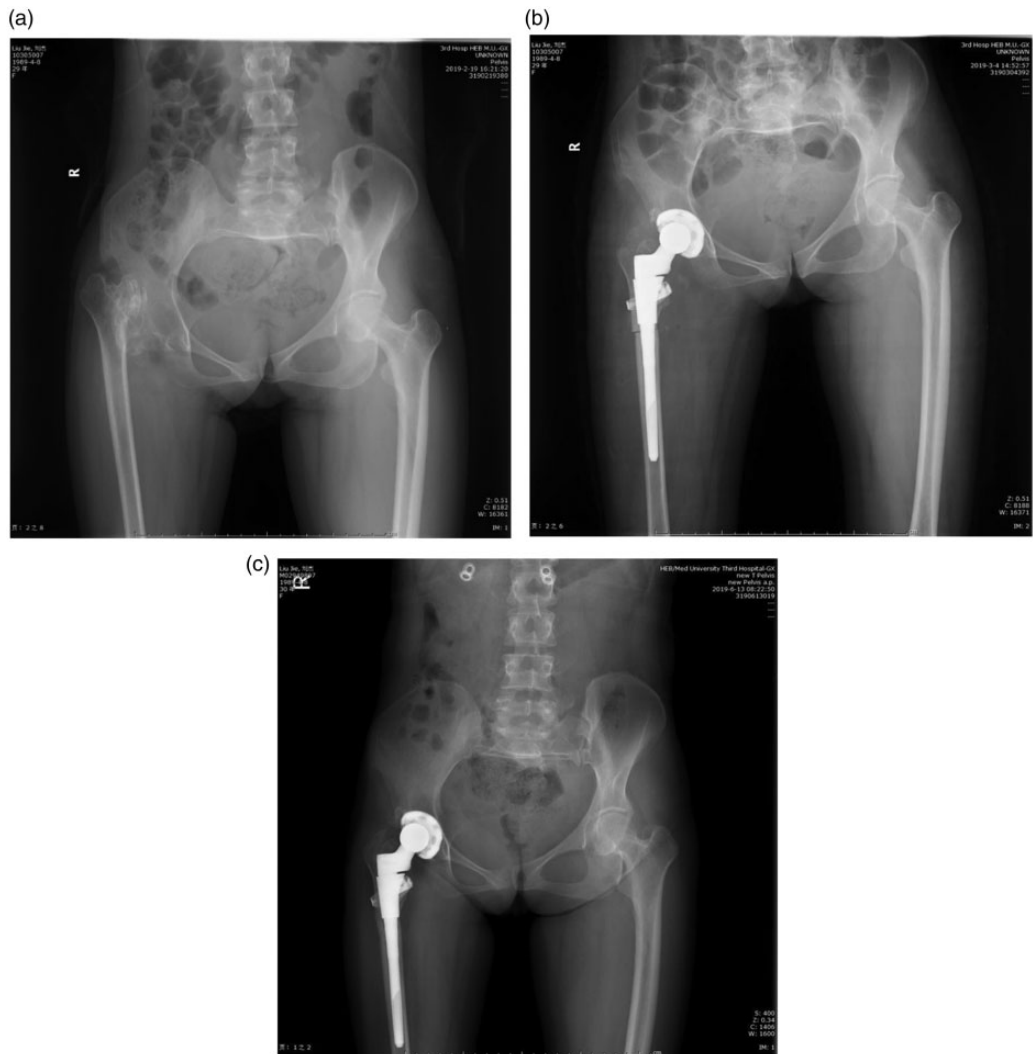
Representative X-ray images of a 29-year-old female patient that was admitted to hospital due to shortening of the right lower limb, as compared with the contralateral side, which had been present for 18 years. She also complained of pain in the right hip that had been present for 2 months. The hip pain was aggravated by physical exertion, but relieved by rest. (a) A preoperative anteroposterior X-ray of the pelvis showed right acetabular dysplasia with high dislocation, thin cortical bone and a narrow medullary cavity. (b) A postoperative pelvic anteroposterior X-ray showed good alignment at the femoral shortening osteotomy and a good position for the prosthesis installation. (c) A postoperative pelvic anteroposterior X-ray at 6 months showed that the femoral shortening osteotomy had healed and the leg length had recovered well. After correction of the pelvic tilt, the cup reached its suboptimal position with an abduction angle of 58°.
